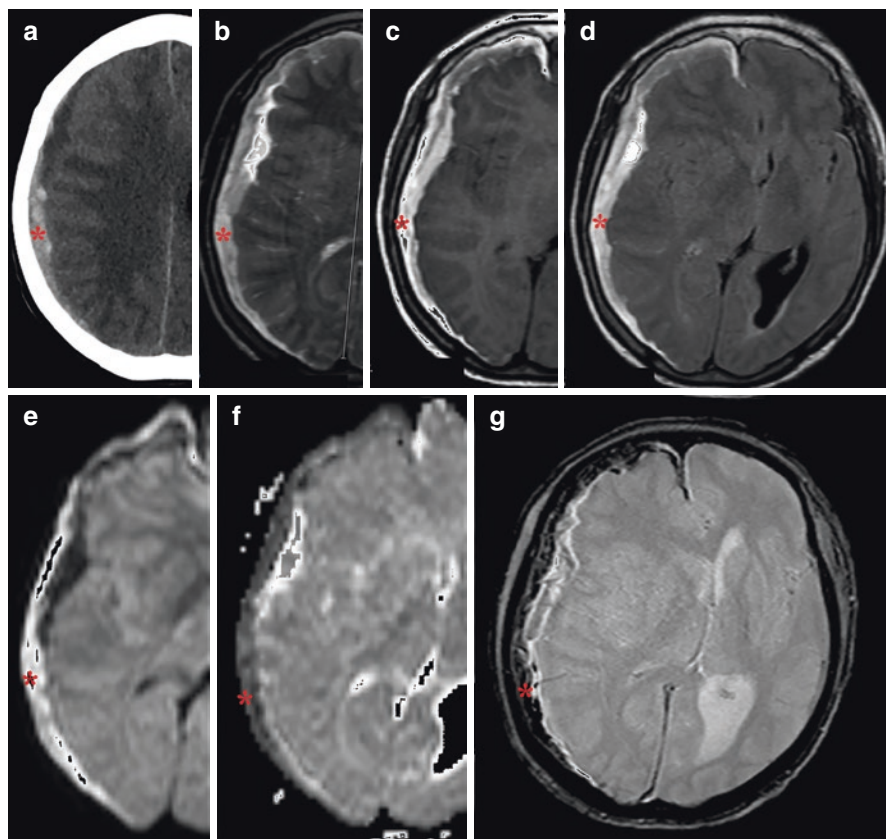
In axial brain CT (a) of a 58-year-old male patient, a subdural collection due to acute or chronic hematoma in the right frontoparietal is observed. In the control MRI examination (b–g) taken 2 days later, an increase in the size of the hematoma was observed. Heterogeneous signal containing hypo-isointense areas on axial T2 (b), hyperintensities due to acute bleeding (red asterisk) in non-contrast T1 (c) are noticeable. In FLAIR images (d), the collection is viewed as hyperintense. Hyperintensity is observed in diffusion-weighted image (e) due to diffusion restriction in acute bleeding areas, and hypointensity on ADC map (f). Chronic blood products (hemichromes and hemosiderin) are selected as hypointense on gradient weighted T2* images (g)
